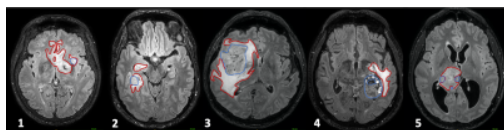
Representative 3D FLAIR images for each patient, with the tumor core and periphery outlined in blue and red respectively. Patient 1 was a 68-year-old female with an IDH wild-type anaplastic astrocytoma. Patient 2 was a 60-year-old male with an IDH wild-type anaplastic astrocytoma. Patient 3 was a 64-year-old male with an IDH wild-type anaplastic astrocytoma. Patient 4 was a 70-year-old male with a brain metastasis from melanoma. Patient 5 was a 23-year-old male with an IDH wild-type anaplastic astrocytoma.
